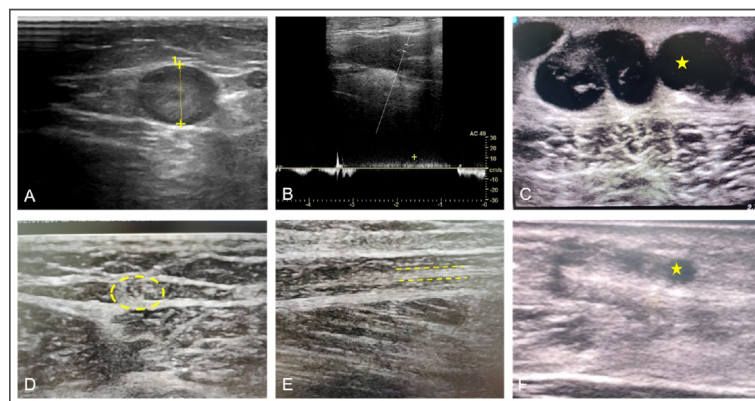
Pre-EVLA ultrasonography images (A, B, C) showing dilated great saphenous vein (GSV) (yellow cursors) (A); reflux at sapheno-femoral junction lasting for more than 0.5secs (yellow cross) (B); and dilated tortuous superficial varicosities (yellow star) (C). 3 months post-EVLA ultrasonography images (D, E, F) demonstrating thrombosed GSV with echogenic contents (yellow dashed circle) (D); linear echogenic cord-like structure – thrombosed GSV (yellow dashed lines) (E); and thrombosed varicosities with echogenic contents within (yellow star) (F).
